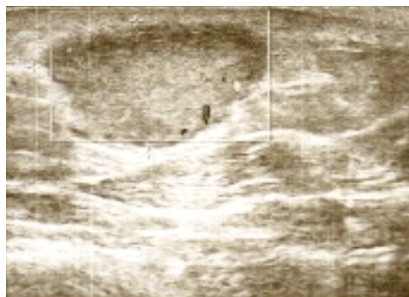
Ultrasound image of the tumor in the transverse axis. The tumor seems to compress the muscle plane without destroying it.
